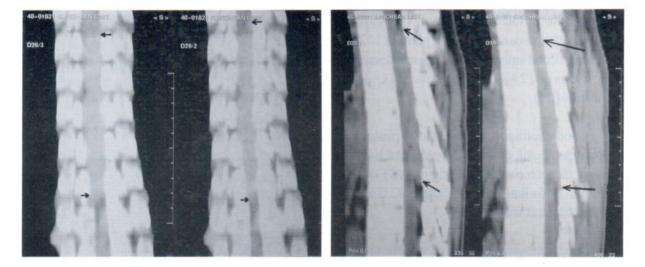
&4 Curve coronal and sagittal reconstruction of non-contrast enhancement CT scan showed hyperdense, nodular-shaped masses, running in the posterior aspect of spinal canal, compressing the thecal sac and displacing the thoracic cord anteriorly.
